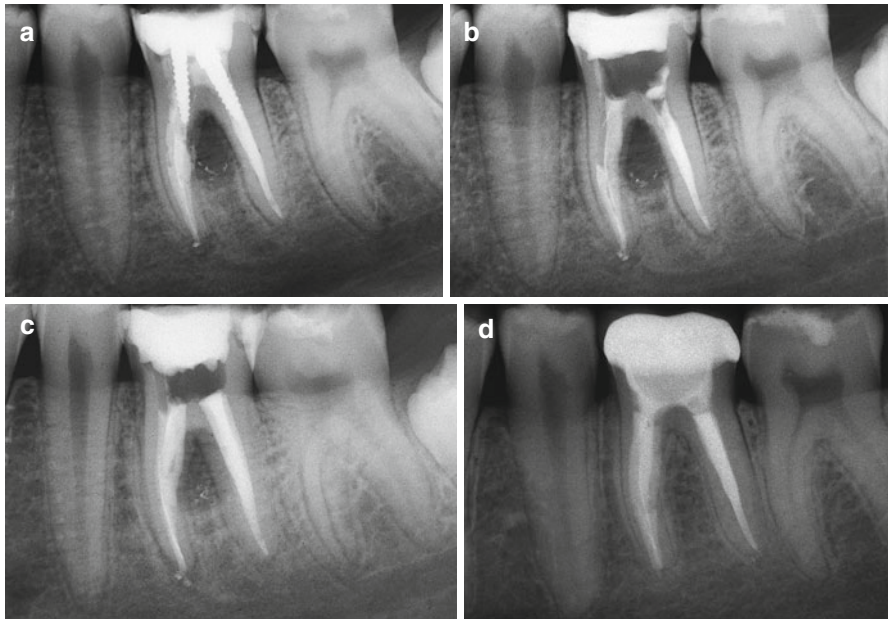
Strip perforation of the mesial root of the lower left first molar, caused by the introduction of a screw post in the mesiobuccal canal. (a) Preoperative radiograph. (b) After nonsurgical retreatment, the obturation with Schilder technique has been made in the distal, in the mesiolingual, and in the mesiobuccal canal, apical to the perforation. (c) Postoperative radiograph: the coronal one-third of the mesiobuccal canal has been completely obturated with MTA, from the perforation up to the orifice. (d) The recall radiograph after 15 years shows the complete healing
